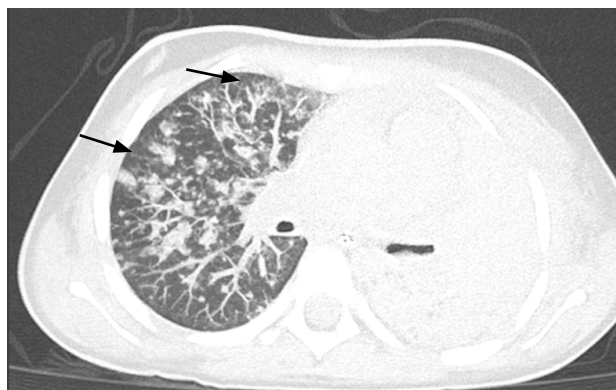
Pulmonary CT scan showing a left white-lung, consistent with diffuse alveolar haemorrhage and areas of ground-glass consolidation.
